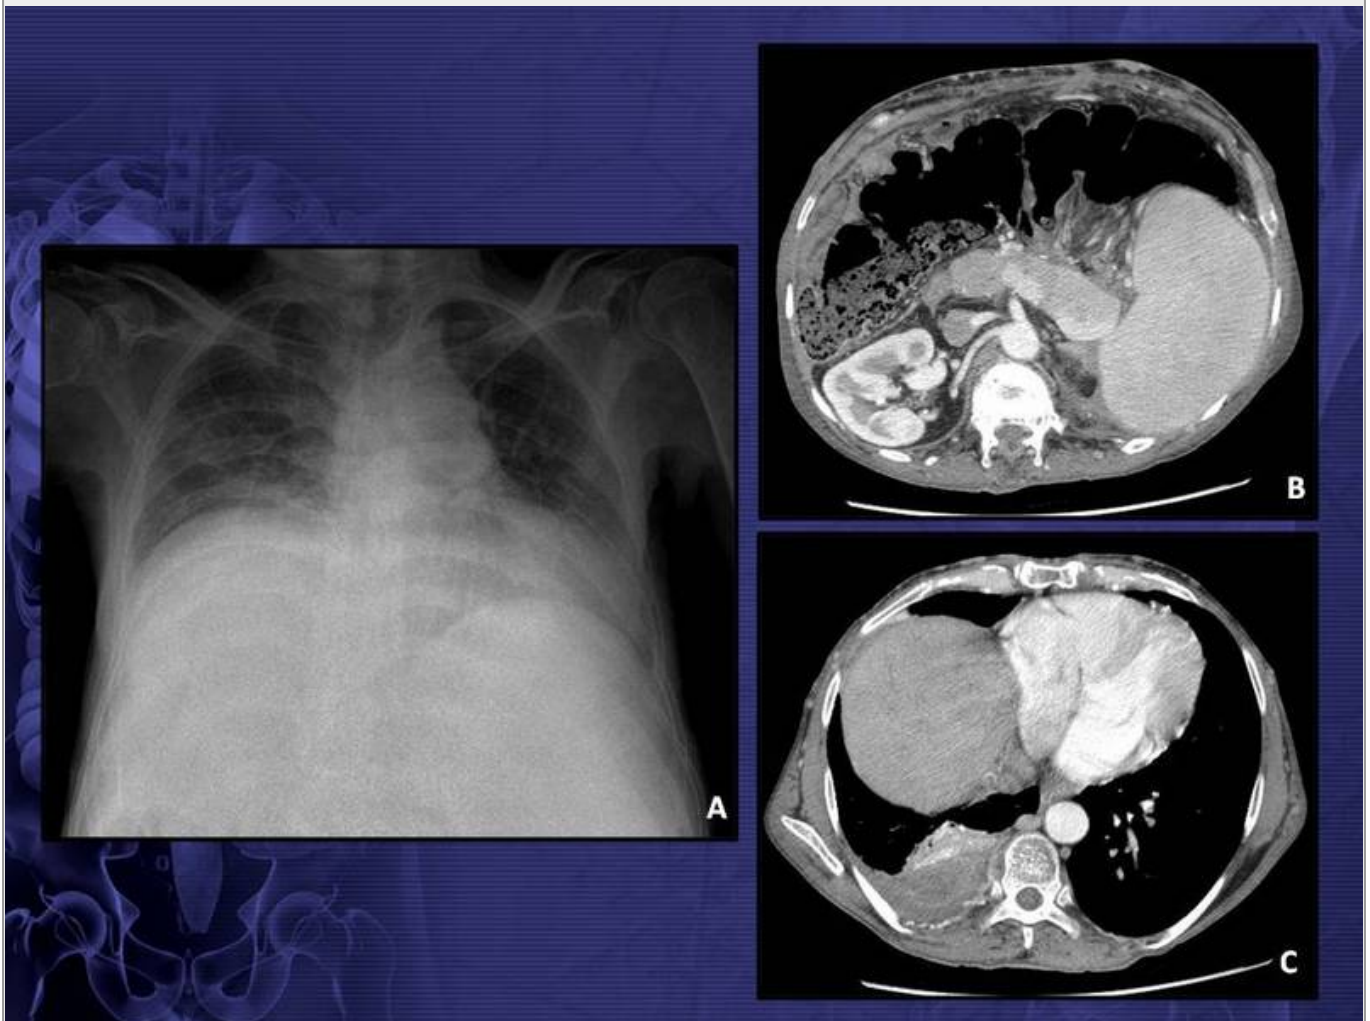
(A) Frontal chest film of a patient with pancreatitis. Note the elevated right hemidiaphragm. (B) CT confirmed the diagnosis and showed the presence of loculated right pleural effusion (C). The right-sided location is atypical.
